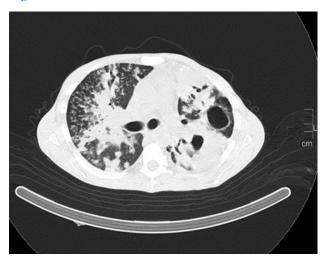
Chest CT in parenchymal window showing nodular condensations and micronodules.
